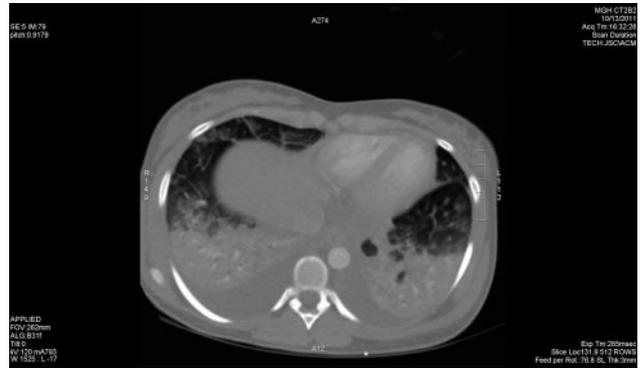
The figure depicts one section of the patient's computed tomography scan revealing diffuse multifocal solid and ground glass opacities throughout both lungs.
